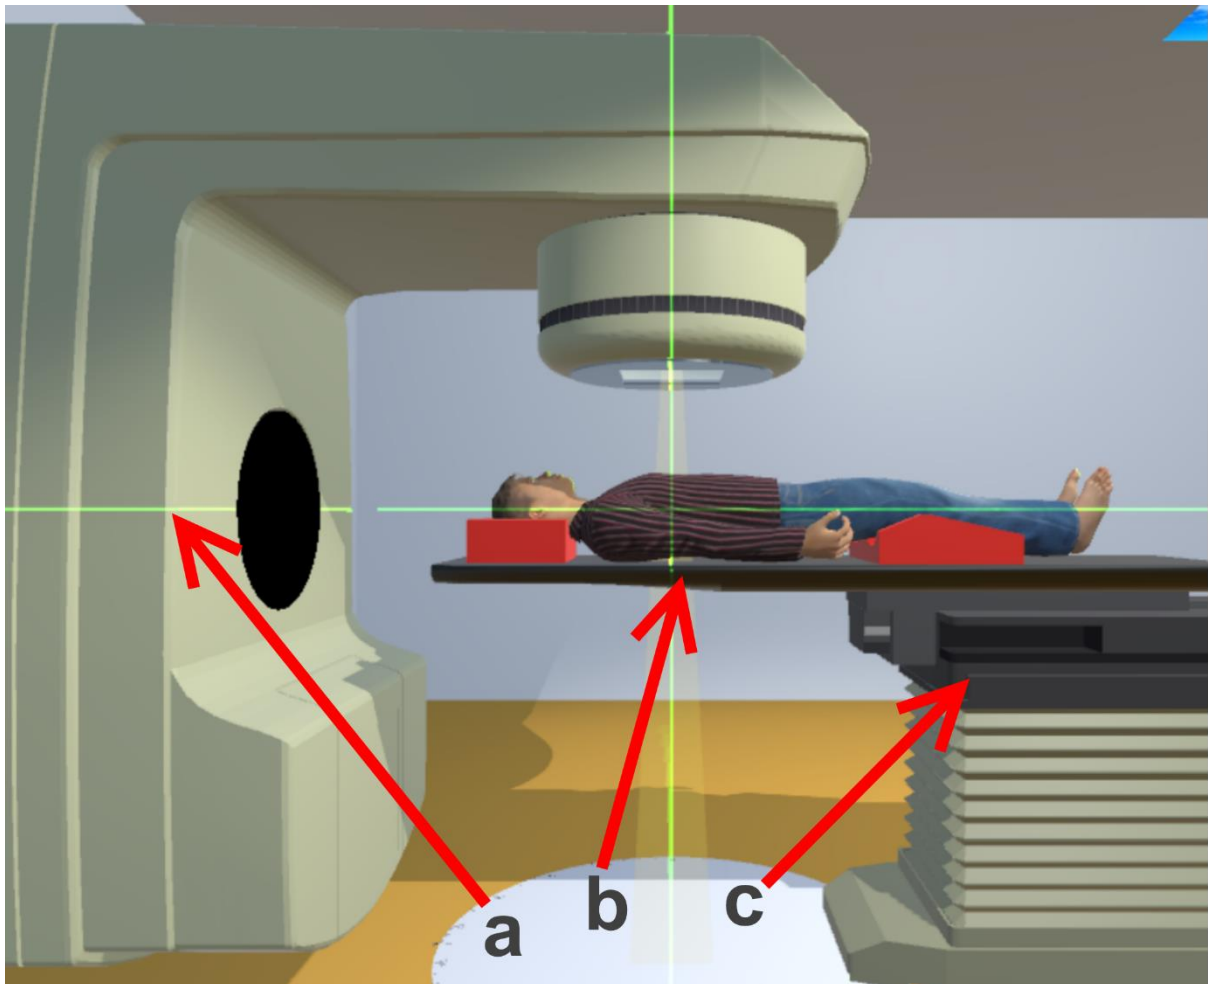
A 3D graphics model of a high energy x-ray treatment unit called a linear accelerator
